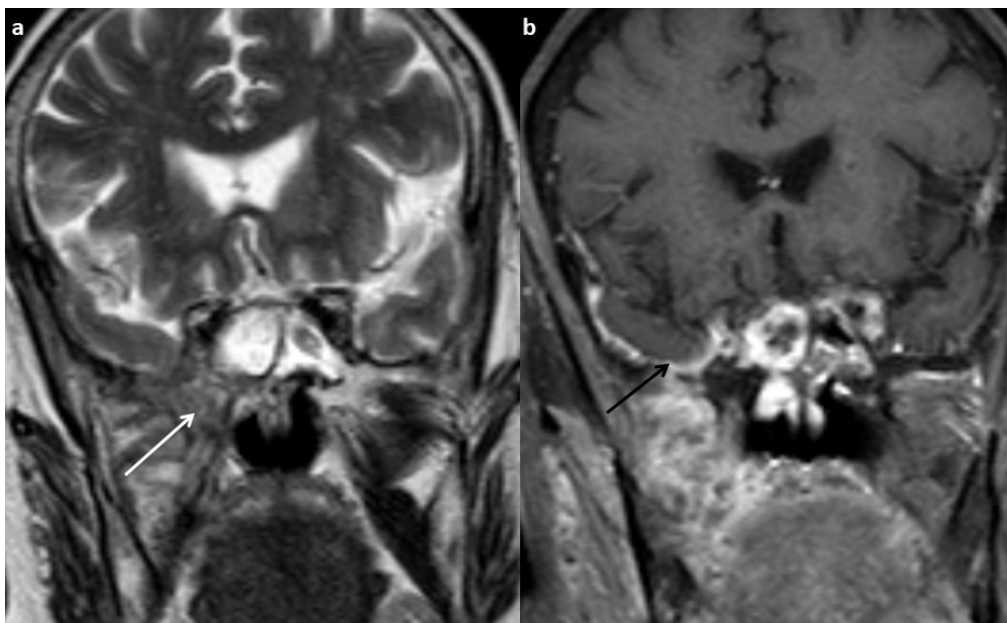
(a) Coronal T2 weighted MRI and (b) Coronal CEMRI show loss of fat signal in the middle skull base on the right side indicative of skull base involvement (white arrow). The right infratemporal fossa and dura along the right temporal lobe show enhancement (black arrow).
